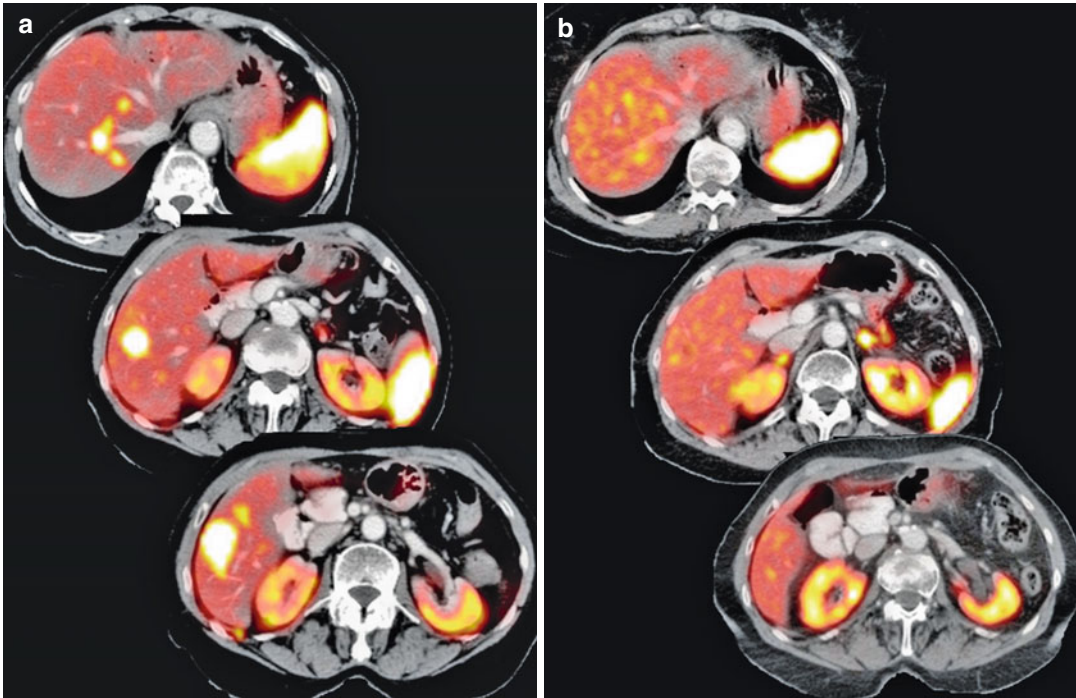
^{68}Ga -DOTA-TATE PET/CT before (a) and after (b) therapy with ^{177}Lu -DOTA-TATE. There is almost complete resolution of the multiple liver metastases
